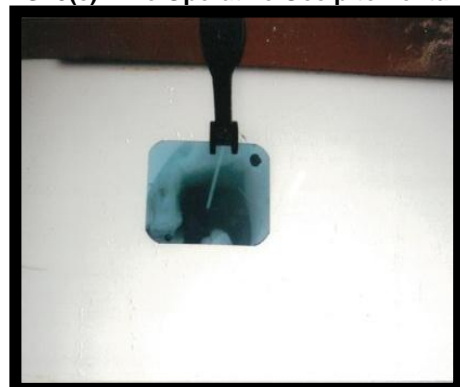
(d) : Preoperative Intraoral Periapical Radiography
